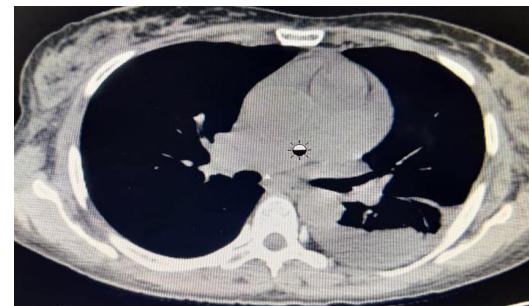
CT Chest : Left sided pleural effusion
